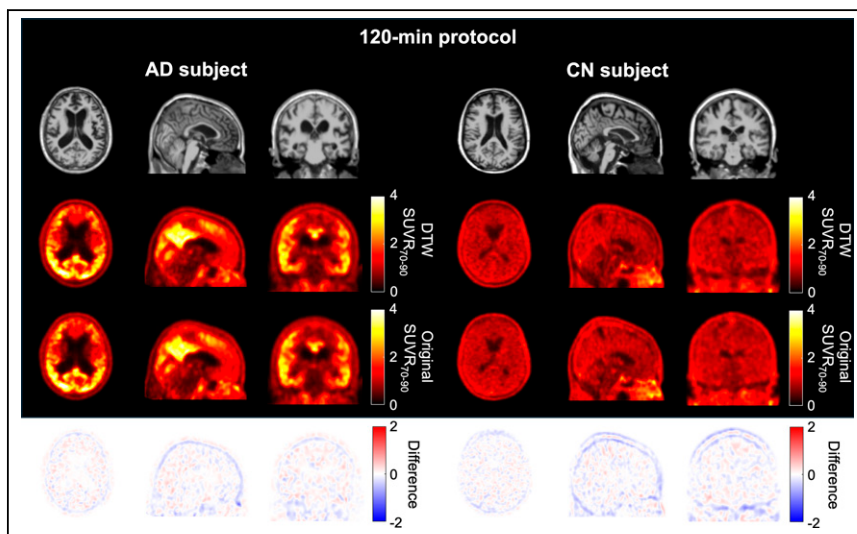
Model-based SUV_{70-90} maps computed for 60-min break with biexponential fit and 120-min scan analysis as well as corresponding MR structural images for same AD and CN subjects as shown in Figure 4. First row shows magnetization-prepared rapid gradient echo as anatomic reference. Second row shows parametric SUV_{70-90} images generated from DTW images. Third row shows original (i.e., from acquired data) SUV_{70-90} images for comparison. Fourth row shows images of difference (SUV_{70-90} DTW – SUV_{70-90} original).
